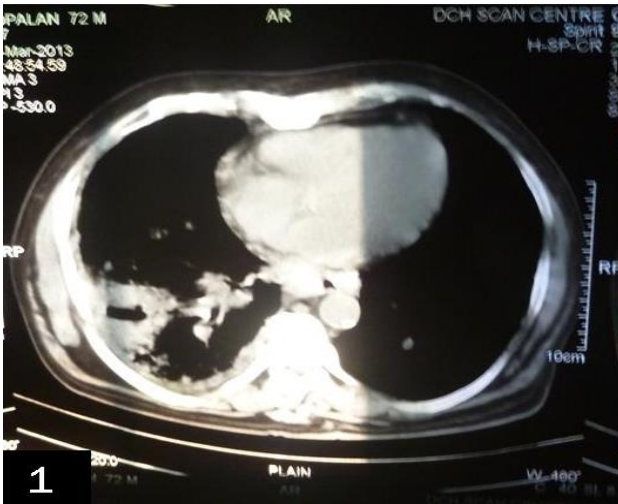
A CT scan with contrast of the chest showing right lower lobe lung mass with central cavitation.
